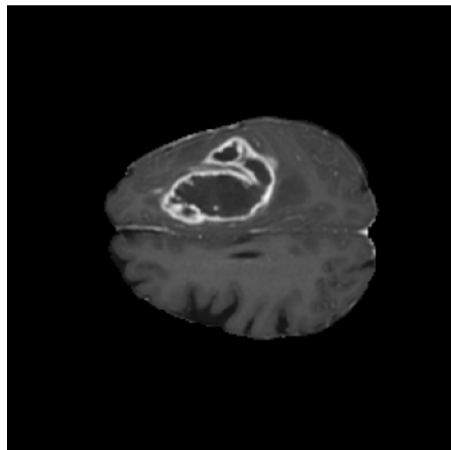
Example of T1-weighted contrast-enhanced MRI sequence.
